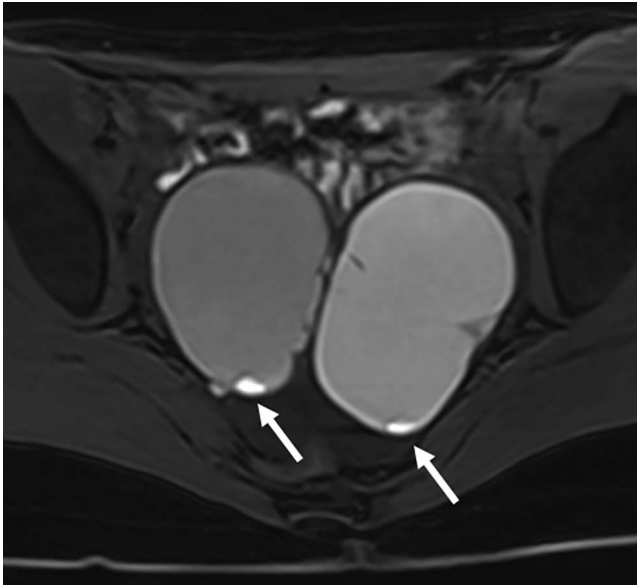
Bilateral hyperintense ovarian lesions on T1-weighted fat-saturated image with the left lesion being slightly more hyperintense compared with the lesion in the right ovary. T1w-hyperintense nodule at the base of both lesions (white arrows).
